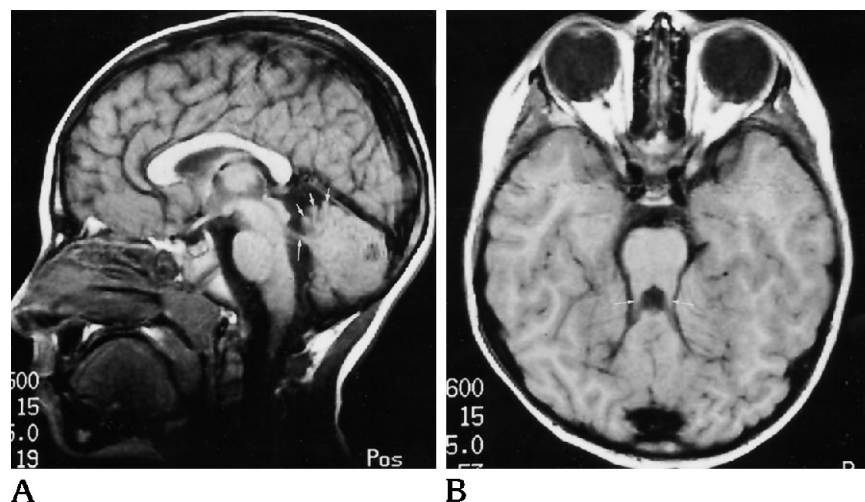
A, Midline sagittal T1-weighted MR image (600/15/2 [repetition time/echo time/excitations]) shows dysgenetic and small lingula, central lobule, and culmen (*small arrows*) of cerebellar vermis. The abnormal superior cerebellar peduncles (*long arrow*) produce flattening of the rostral fourth ventricle, which is abnormal in shape. The foramen of Magendie is open, and no hydrocephalus is present. The configuration of the midbrain and the corpus callosum is normal. The area of low signal intensity in the posterior cerebellum is of uncertain cause.
